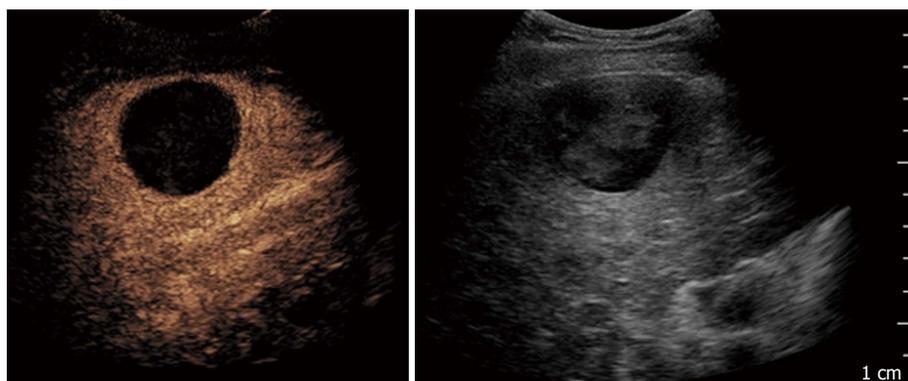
Contrast-enhanced ultrasound performed after 1 mo in a 71-year-old man treated with trans-catheter arterial chemo-embolisation: On the left side complete necrosis is depicted as an avascular area; on the right side B-mode imaging of the treated area.
